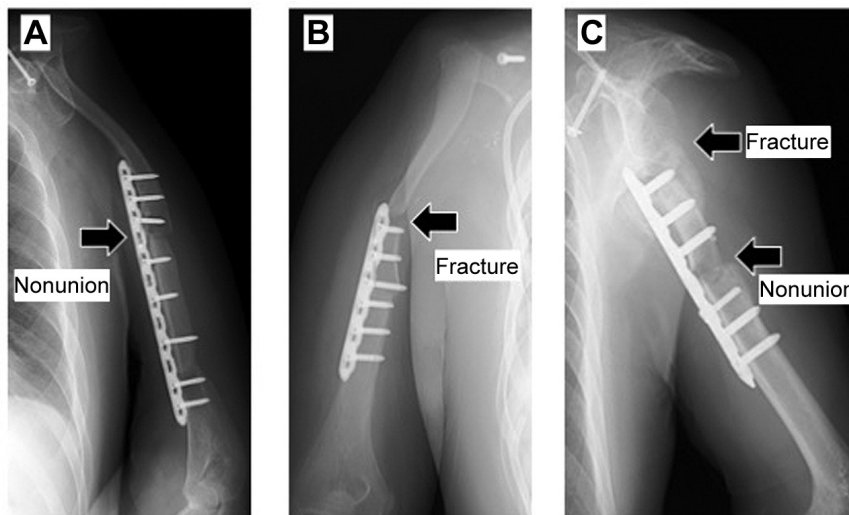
Postoperative X-ray of three cases with complications. A: Patient 2: Proximal portion in reconstruction with vascularized fibular autograft did not achieve union but the distal portion achieved bone fusion at 25 months after surgery. B: Patient 4 had a fracture of the clavicular segment at 3 months after surgery, leading to revision surgery for internal fixation and bone graft. C: Patient 6 had a fracture of the clavicular segment and non-union at 5 months after surgery. However, there was no need for revision surgery due to a lack of both pain and disability.
